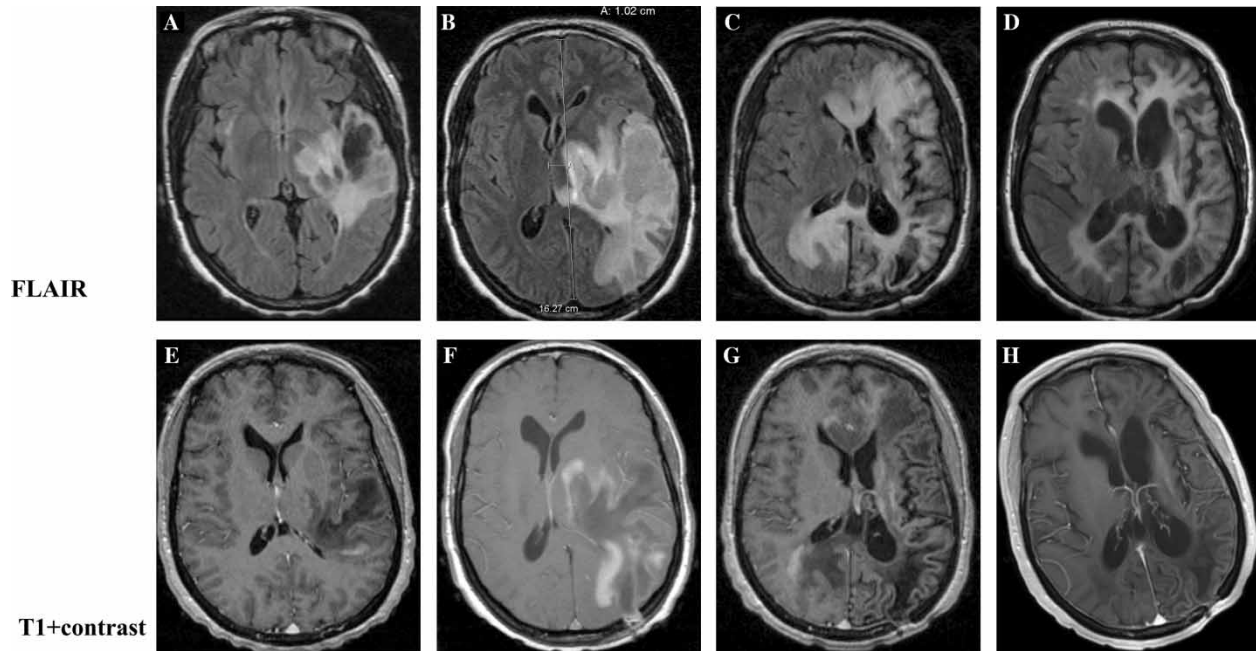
Serial MRI scans of tumefactive inflammatory CNS demyelinating disease in an AIDS patient treated with HAART. (A) Initial FLAIR MRI scan obtained 1 month after neurological symptom onset showed an infiltrative appearing lesion with irregular hyperintensity and a central hypointense region. Contrast enhancement was detected at the posterior lesion rim (E). (B) Follow-up FLAIR MRI scan 5 months after the symptom onset showed enlargement of the lesion with mass effect and a midline shift. Areas of abnormal contrast enhancement were noted at the periphery of the new lesions (F). (C) A third scan at the time of clinical worsening showed a significant interval enlargement of the lesions with extension of the previously noted signal abnormalities through the corpus callosum and involvement of the right hemisphere. The left frontal lobe demonstrated new signal abnormalities. Encephalomalacia was noted within the left temporal, parietal, and occipital lobes. Areas of irregular contrast enhancement were noted at the periphery of the new lesions (G). (D) Most recent imaging study, 36 months following symptom onset, showed stable white matter changes and atrophy, with no contrast enhancement (H).
